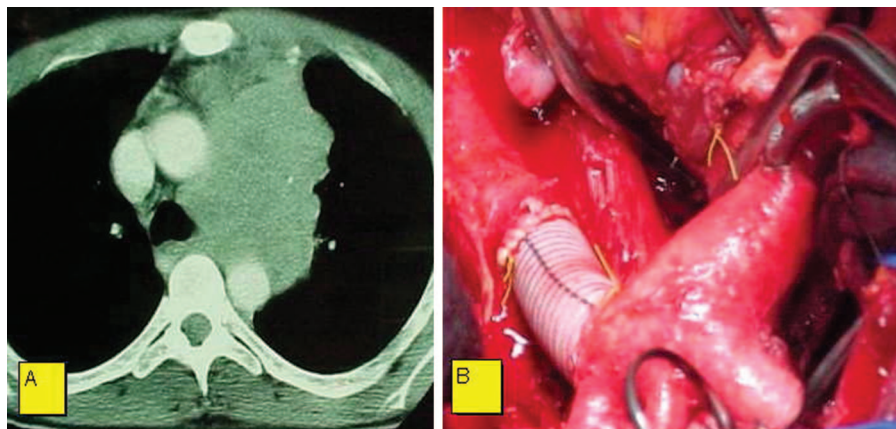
A, CT scan disclosing left thymic carcinoma after chemotherapy. B, Intraoperative view of thymic carcinoma resection with aortic resection and prosthetic reconstruction and pulmonary artery resection and direct reconstruction.
